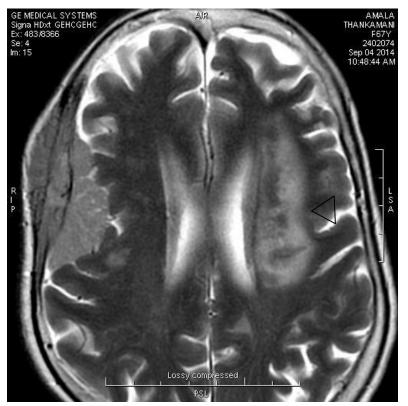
MRI SCAN - In the right hemisphere a space occupying intracranial extra-axial lesion buckling the right parieto-temporal brain parenchyma, expanding the intra-diploic region and extending into extra cranial soft tissue (*arrow*). In the left hemisphere a sub acute white matter infarct noted in the parietal region (*arrow-head*).
